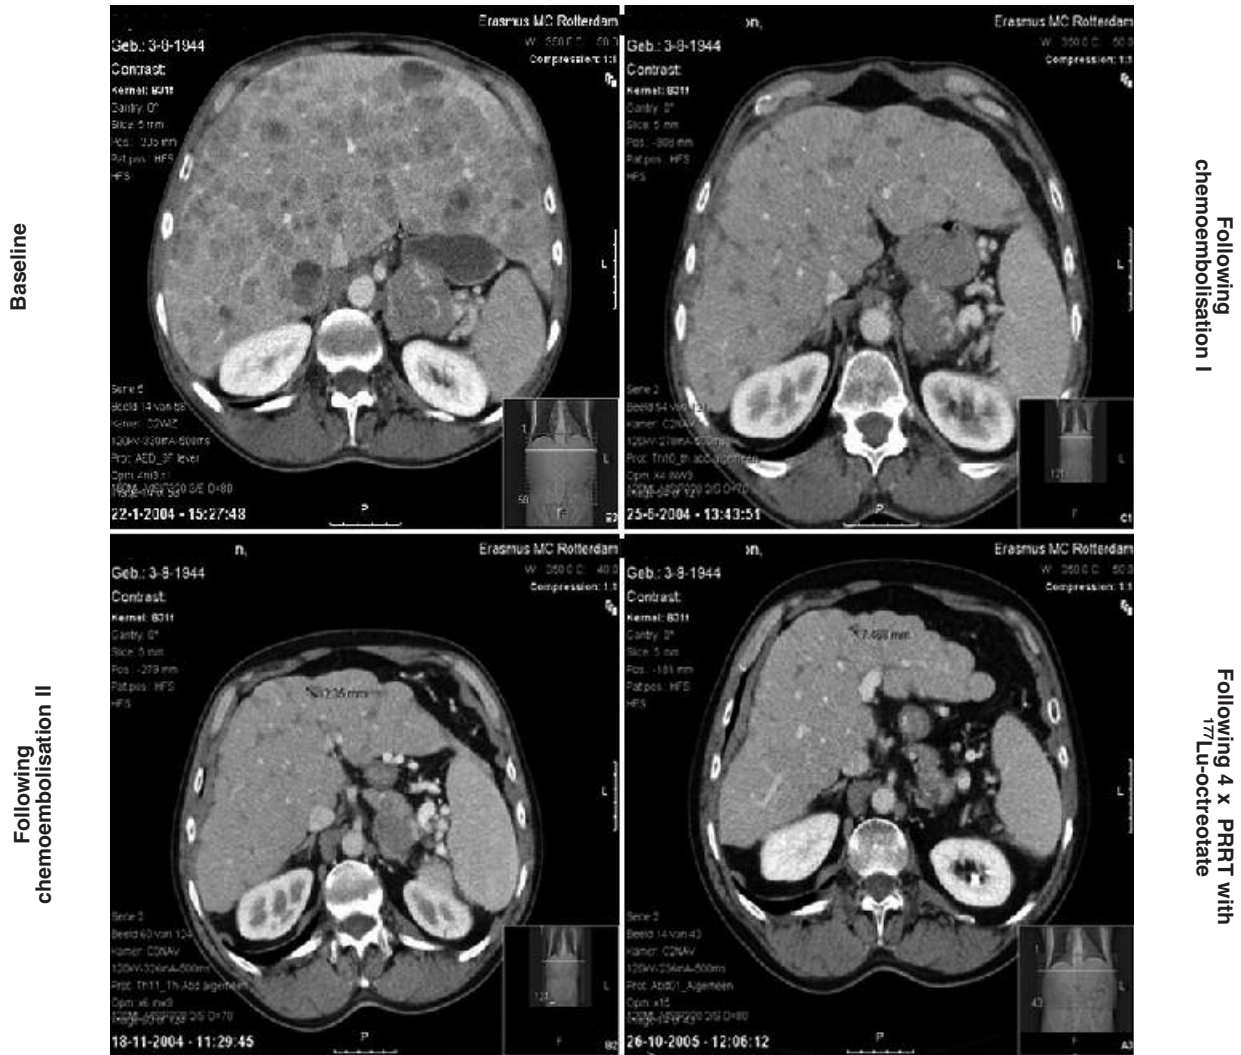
CT images of a metastatic nonfunctioning pancreatic neuroendocrine tumor in a 59 year-old male patient at baseline, following the first and the second cycle of chemoembolization and following 4 cycle of peptide radioreceptor therapy (PRRT) with ¹¹¹Lu-otcreotate.
